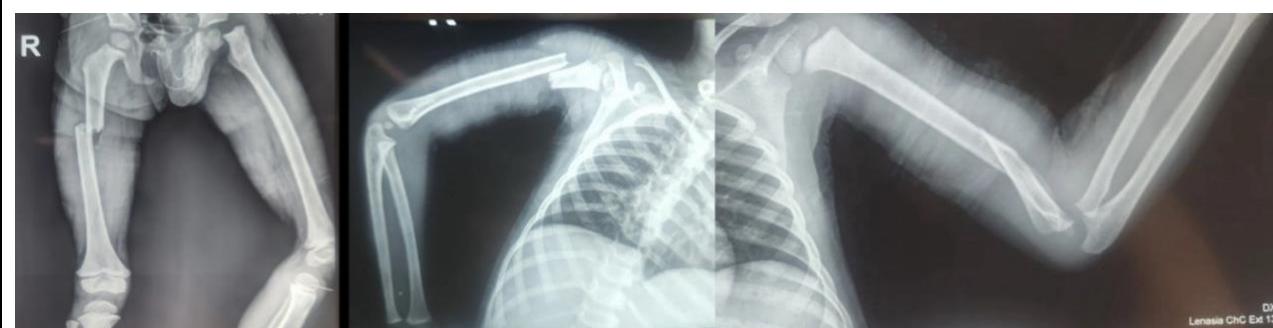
Preoperative radiographs demonstrating fractures involving all four limbs, including a right midshaft femoral fracture, a left proximal femoral physeal fracture (Delbet Type I), a right proximal humeral extraphyseal fracture, and a left distal humeral extraphyseal fracture.
